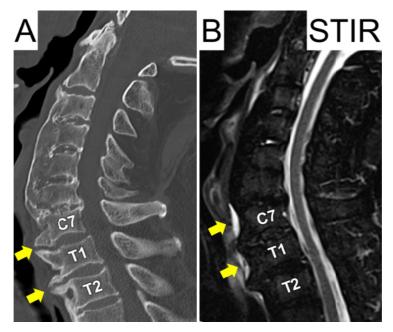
Computed tomography (CT) and magnetic resonance image (MRI) at initial visit.
